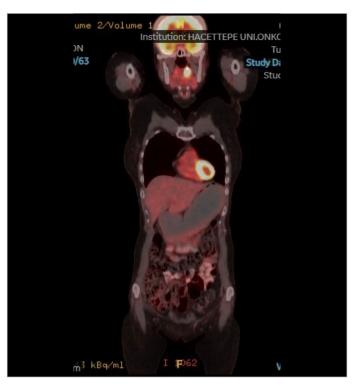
PET/CT scan showed asymmetric thickening and intense FDG uptake in the left palatine tonsil.
